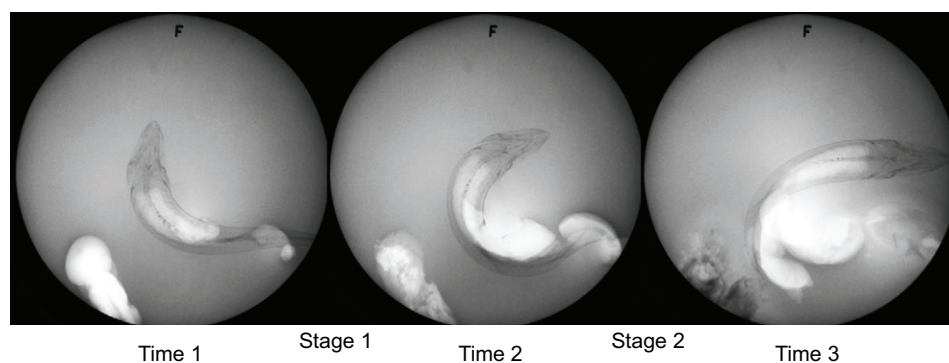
Three frames of X-ray video showing the three points in time used to investigate the pattern of bending for each startle response. Time 1 corresponds to the middle of stage 1 of the startle response, time 2 corresponds to the transition between stage 1 and stage 2, and time 3 corresponds to the middle of stage 2. The brighter areas of overexposure are indicative of a change in water depth resulting from the movement of water due to the visual stimulus (lower left corner) and the movement of the fish.
